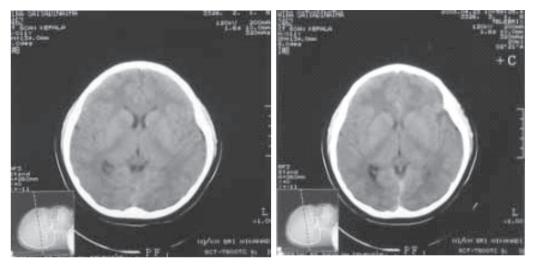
Head CT scan reevaluation 2 months after treatment showing no cyst and calcification
